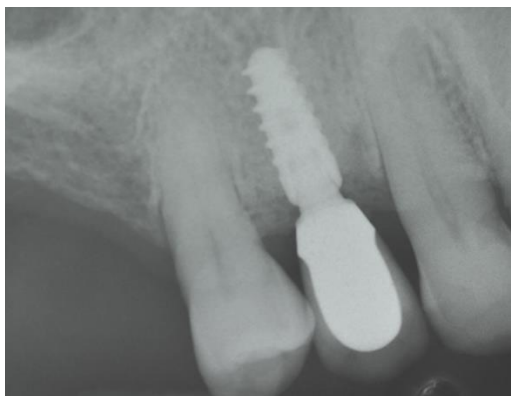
Case 1. Control X-ray at 4 months.
